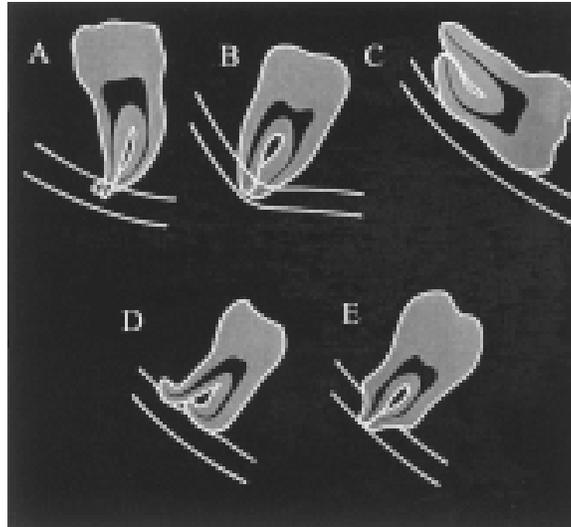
Five radiographic signs suggesting juxtaposition of the mandibular canal to the third molar roots, as described by Rood and Shehab (1990)
